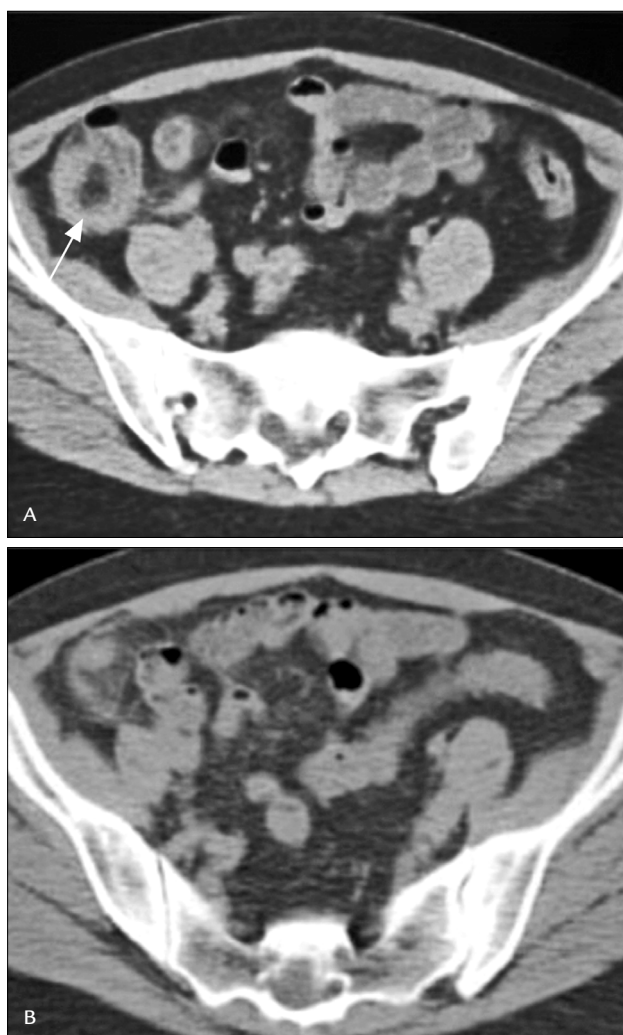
Computed Tomography. Acute appendicitis. (A) Thickening of the cecum (arrow), (B) blurring of peritoneal fat and thickening of the appendix.
